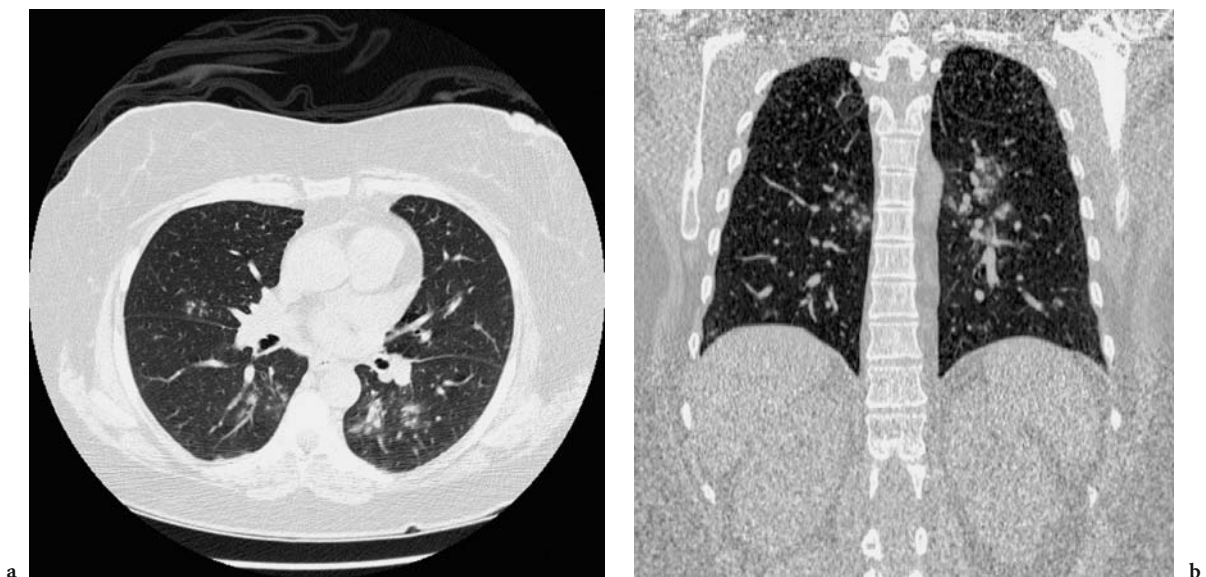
Respiratory syncytial virus (RSV) infection in a 56-year-old woman after bone marrow transplantation. a Chest CT scan (collimation 16×1.25 mm) shows multiple centrilobular nodules located predominantly in both lower lobes. b Coronal reformatted image depicts craniocaudal distribution of centrilobular nodules
